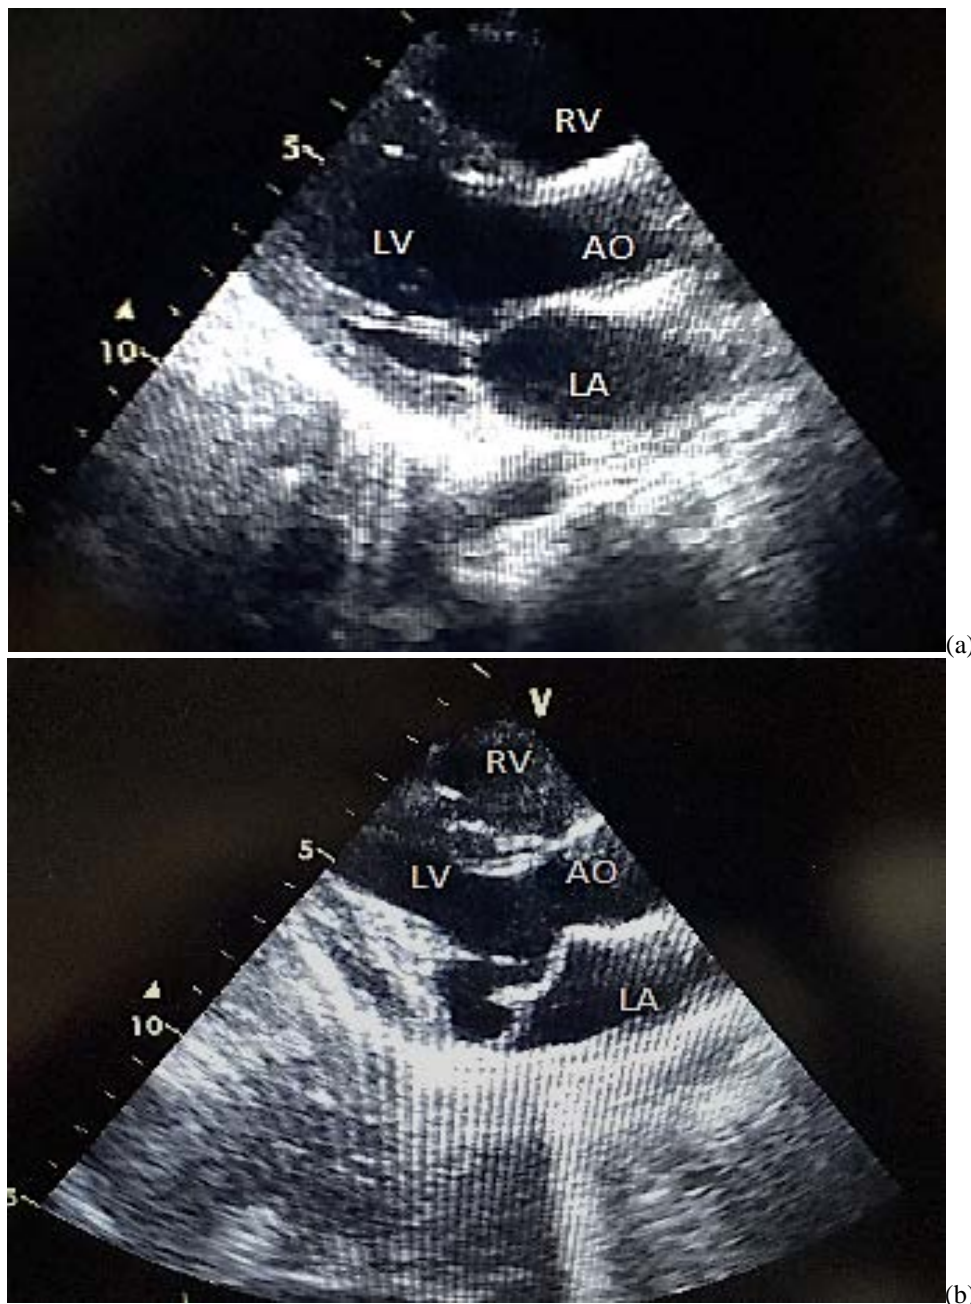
(a,b). Two-dimensional echocardiographic long axis parasternal view of mitral valve prolapses (a) and normal mitral valve (b). LV: left ventricle, LA: left atrium, RV: right ventricle, Ao: aorta.
